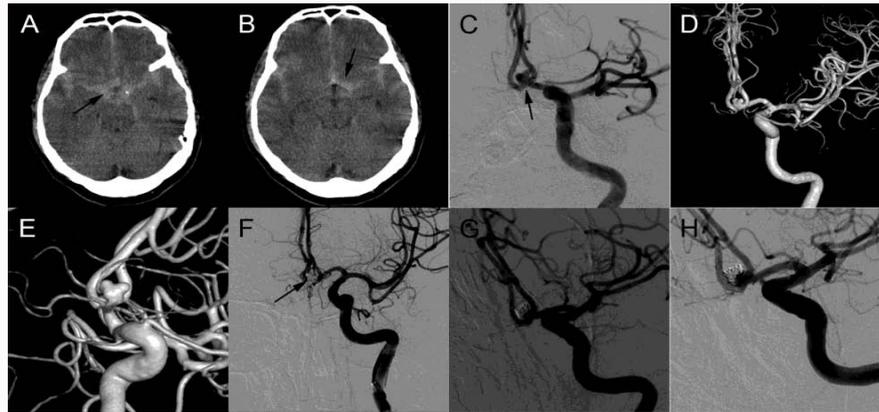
Images from a 48-year-old man who underwent single coiling treatment for a saccular aneurysm located in the anterior cerebral artery (ACA). (A and B) Preoperative computed tomographic images showing subarachnoid hemorrhage and intraventricular hemorrhage; modified Fisher grade 3. (C–E) Preoperative angiograms (C) and three-dimensional reconstruction (D and E) confirming an irregular saccular aneurysm located in the ACA. (F) Immediately postoperative angiograms showing a near-completely occluded aneurysm. (G) Three-month postprocedural angiograms showing contrast media filling the aneurysmal neck. (H) Eight-month postprocedural angiograms showing contrast media filling the aneurysm neck, and no substantial change compared with 3 months postoperatively.
